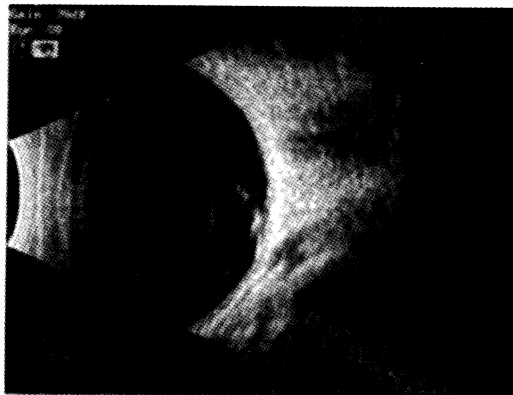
B-scan ultrasonography of right eye
